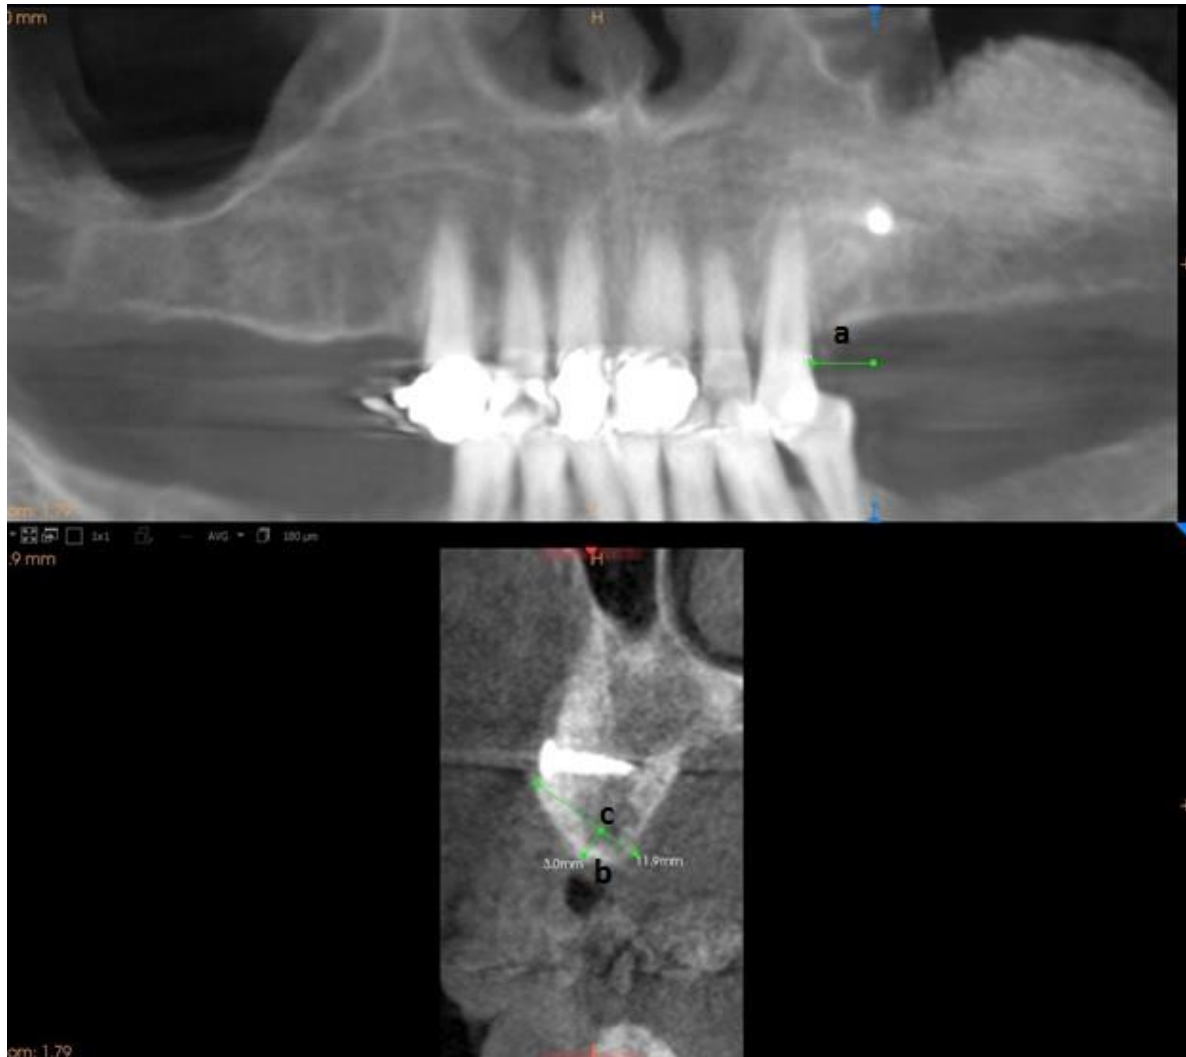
Postoperative CBCT scan taken 7 months following surgery demonstrating linear measurement in the same area as Figure 2. a) linear measurement from distal surface of terminal tooth to area of future implant placement (same measurement as the pre-operative scan), b) measurement to 3mm below the alveolar crest, c) linear measurement of horizontal width.
